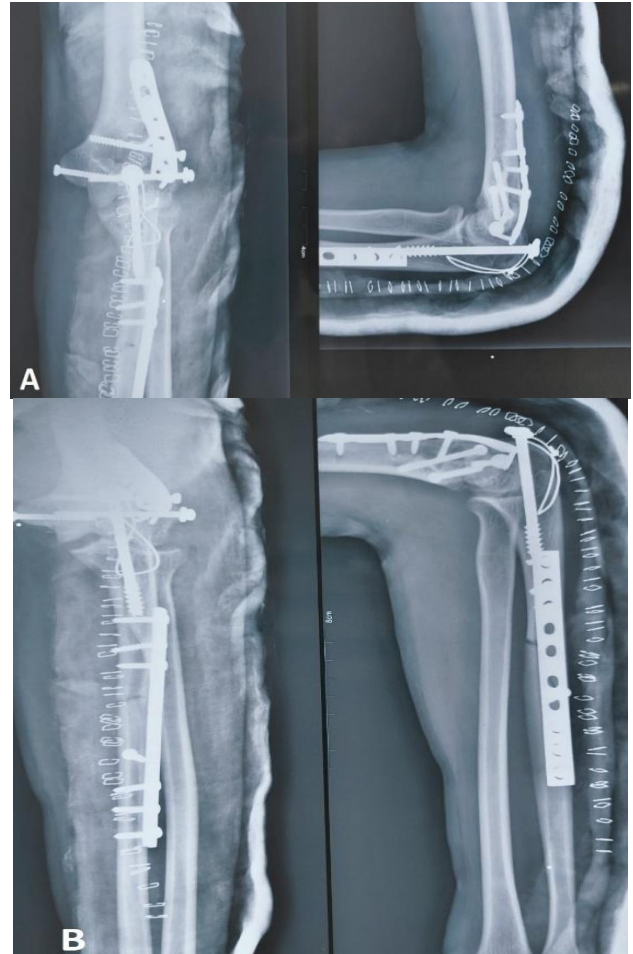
(A and B): Immediate post-operative plain X-ray of left elbow and forearm anteroposterior and lateral view showing the reduction and stable fixation of the fractures.
